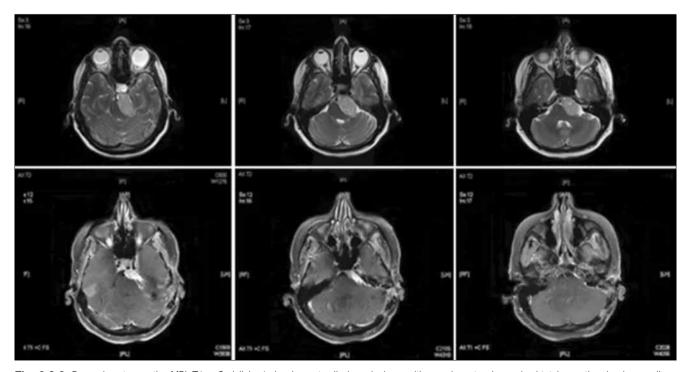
Pre and post-operative MRI (T1 + Gadolinium) showing petroclival meningioma with superior extension and subtotal resection leaving small residual severely adherent to 3 and 6 cranial nerves. The surgical approach selected was the modified "Hakuba" presigmoid retrolabyrinthine combined approach.
